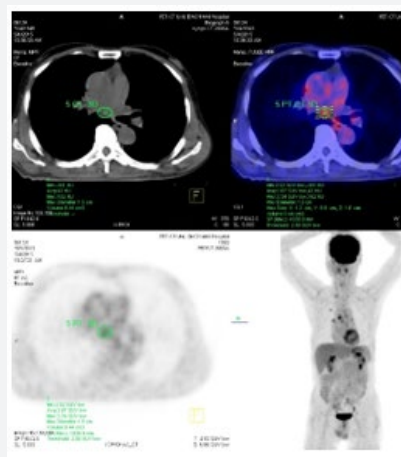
A mediastinal was detected by PET/CT as a metastasis lesion with tumor diameter: 1.5 cm and MTV: 0.44 ml.
